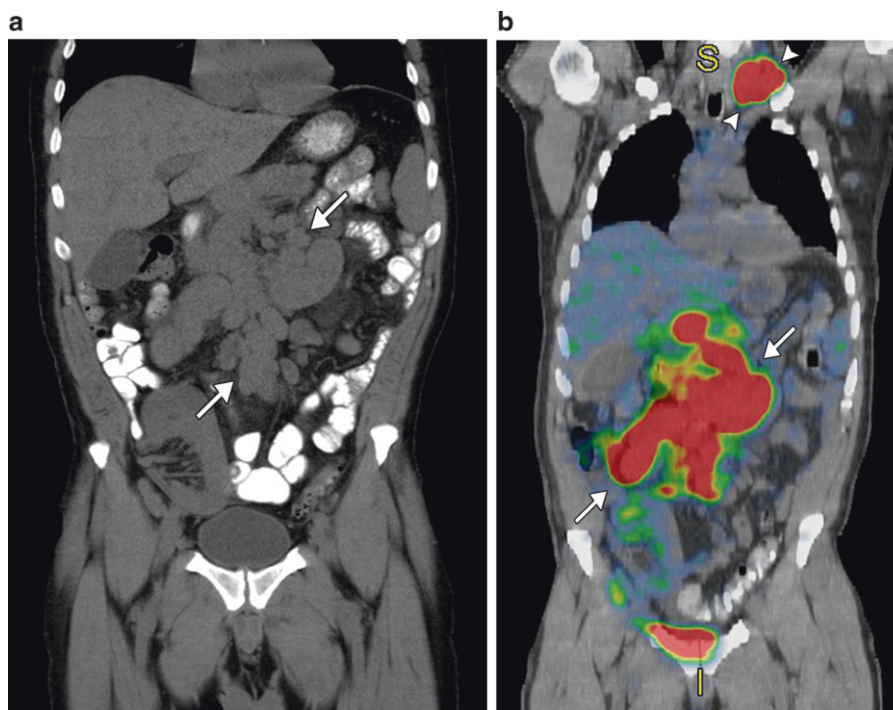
B cell lymphoma in a 65-year-old, 5 years after renal transplant. (a) Unenhanced coronal CT shows multiple enlarged lymph nodes (arrows) in the mesentery. The renal transplant is not involved.
